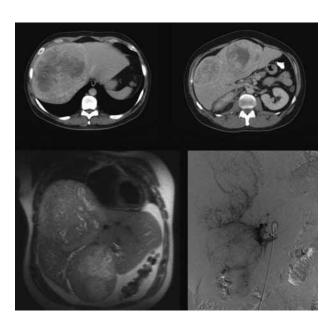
Multifocal, voluminous metastases of the liver and right adrenal gland on axial contrast-enhanced computed tomography (top row), coronal T2-weighted MRI (lower left) and conventional angiography (lower right). Note the hypervascularity of the lesions and foci of necrosis.
